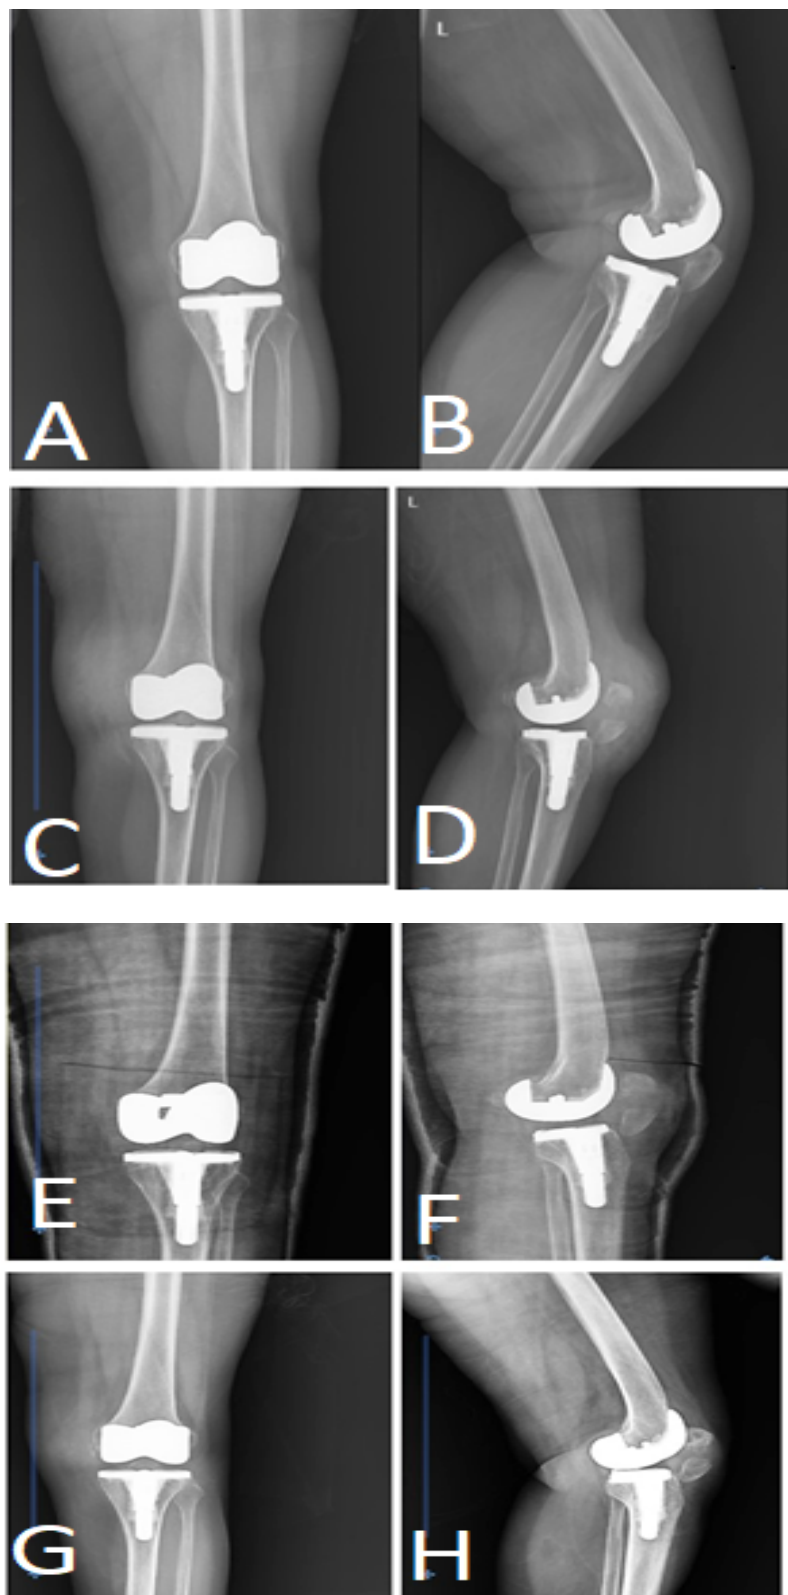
A and B) AP and lateral radiography of knee before injury, C and D) Radiography of knee after injury, E and F) Radiography after six weeks follow-up, G and H) Radiography after three months follow-up
